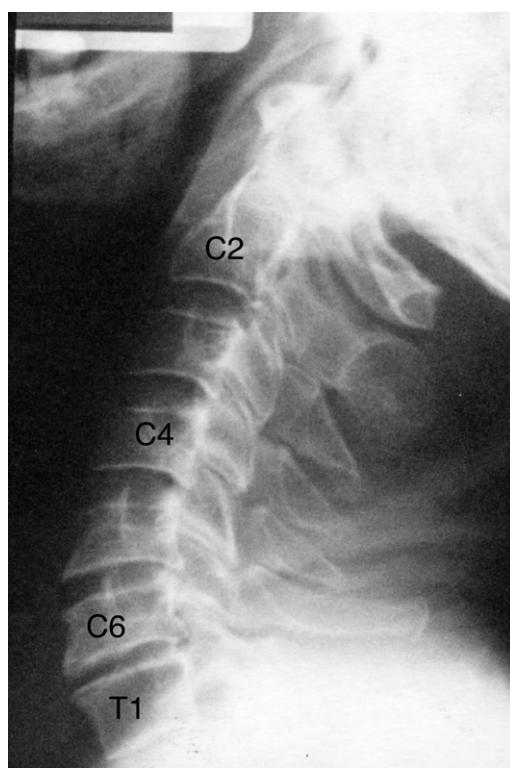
Cervical spine flexion plain X-ray image. Note (i) the slight anterolisthesis of C2 on C3, (ii) the angulation at the C4, (iii) what appears to be an old compression fracture at C6 as suggested by some loss in height of the vertebral body when compared to the height of adjacent vertebral bodies, and (iv) anterior lippling of the vertebral bodies at the C5-6 and C6-7 levels.
